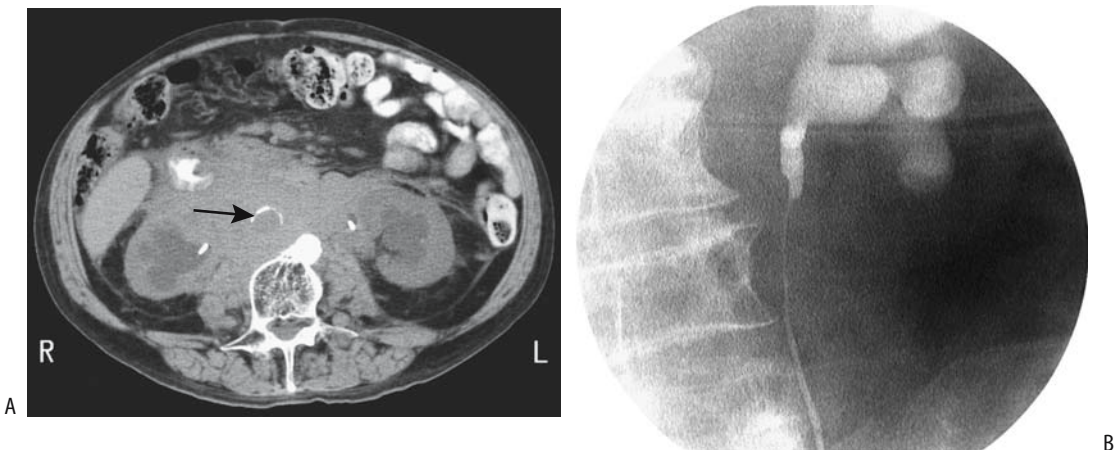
Lymphoma obstructing ureters. A: CT identifies a bulky retroperitoneal infiltration encasing a calcified aorta (arrow). Bilateral ureteral catheters are in place. B: Retrograde urethrograph reveals a long extrinsic left ureteral obstruction. (Courtesy of Patrick Fultz, M.D., University of Rochester.)
